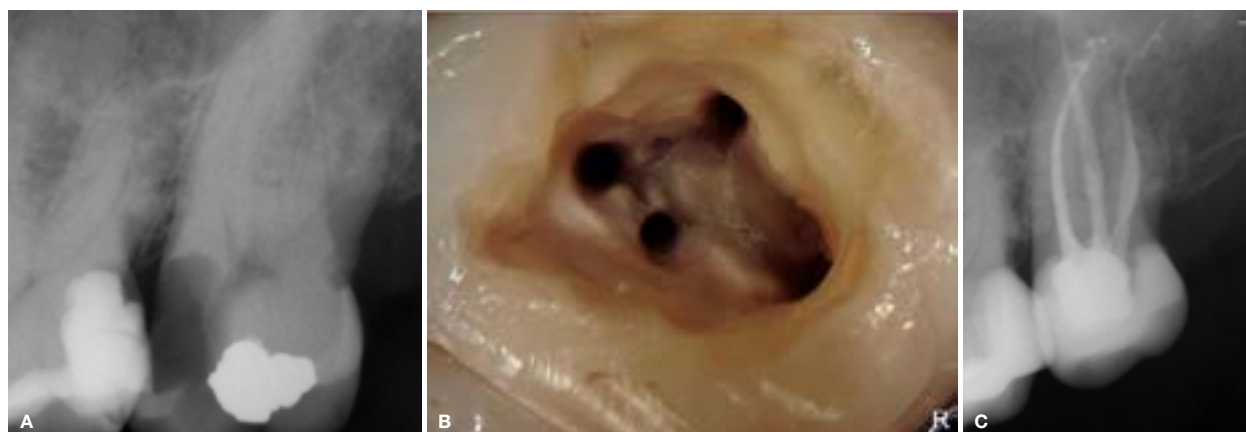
(A) Preoperative periapical radiograph of the left maxillary second molar. (B) Magnified view of the pulp chamber showing the four root canal systems that were located. (C) Final result after root canal obturation.
